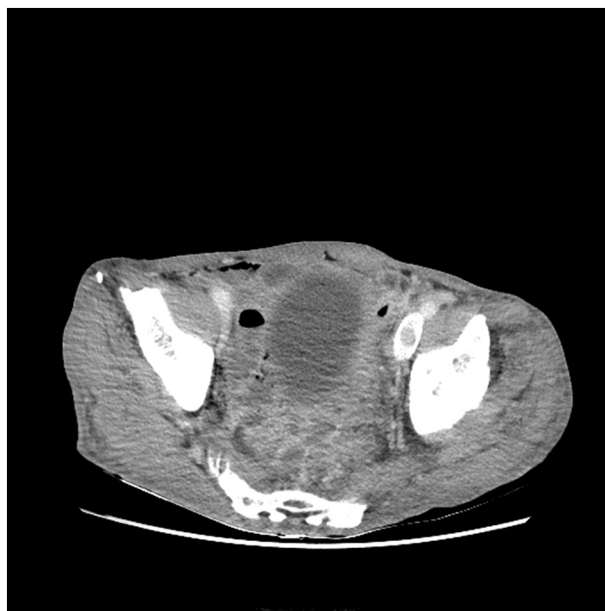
Follow-up contrast-enhanced CT image six months after the procedure. Patent external iliac vein bare stent and resolution of previous left pelvic hematoma were noted.
